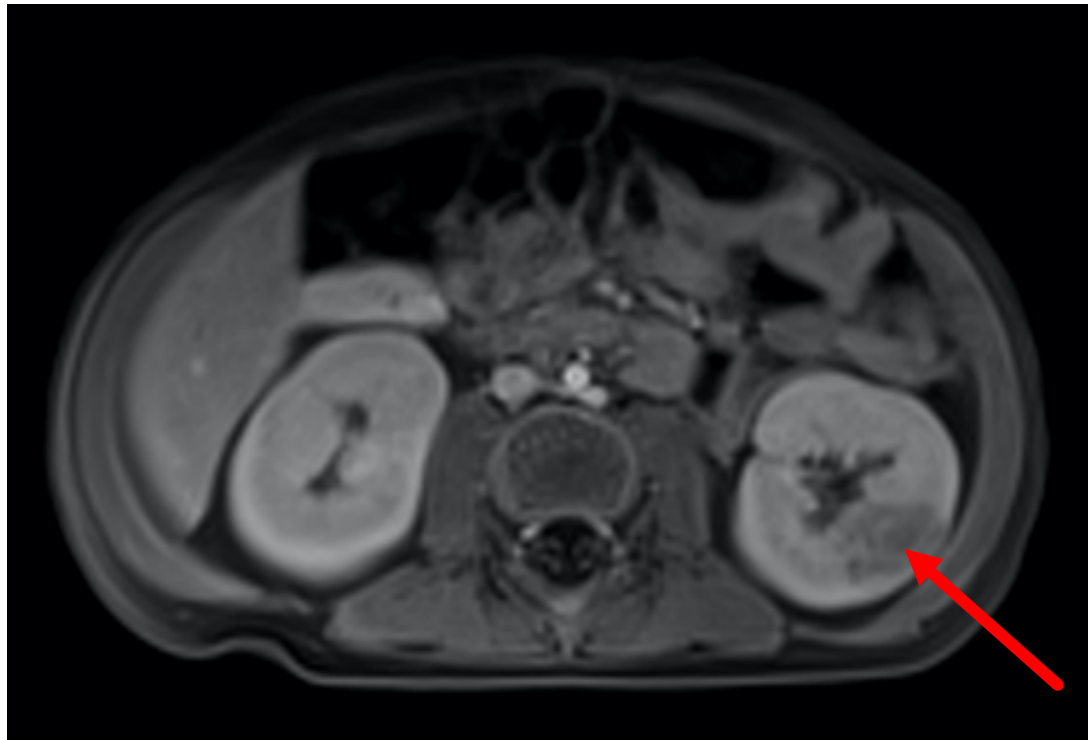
Figure a Left renal midpole lesion on preoperative MRI
